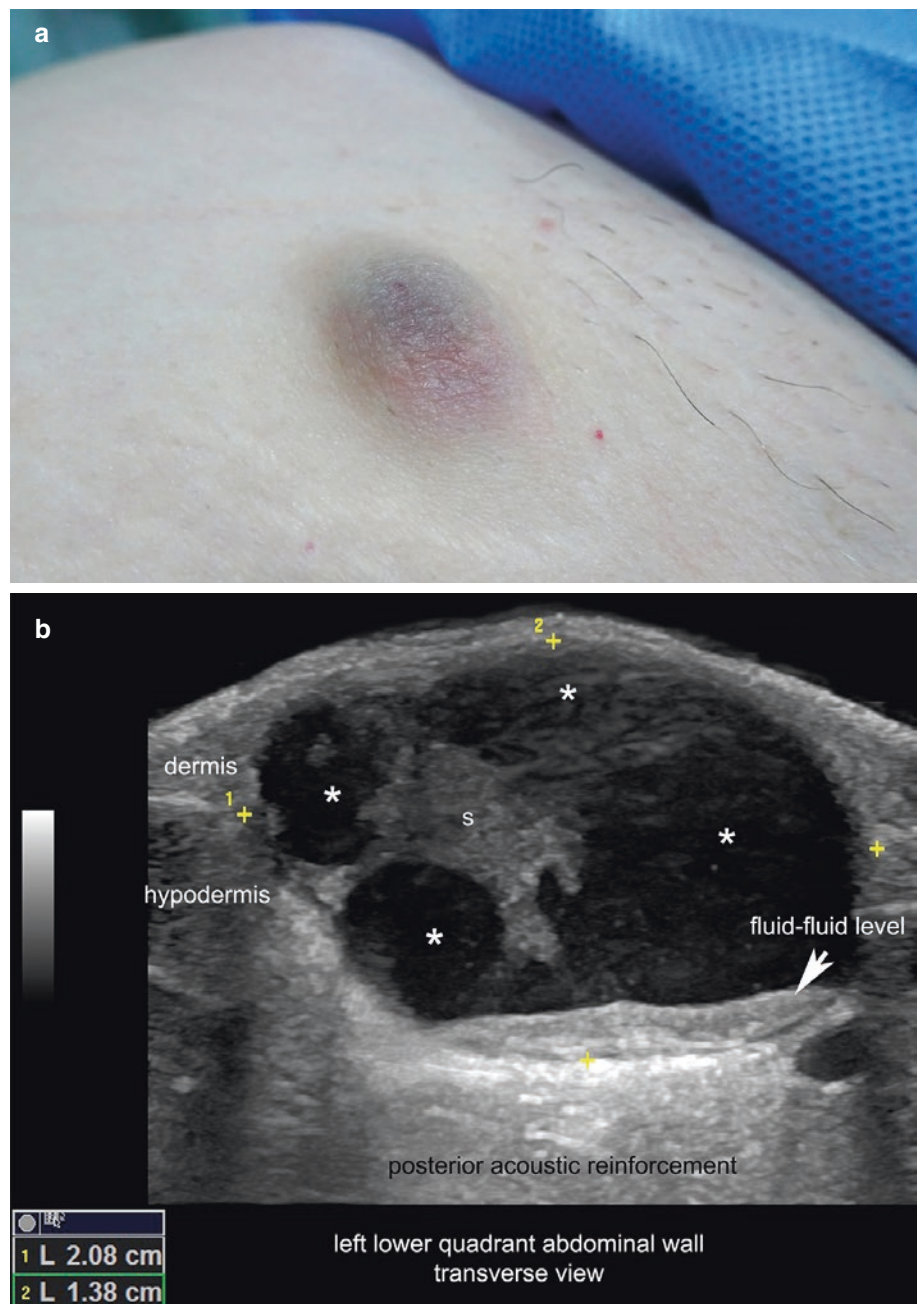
Apocrine hidradenoma. (a) Clinical image at the left lower quadrant of the abdominal wall. (b) Ultrasound (greyscale; transverse view) demonstrates a well-defined, oval-shaped, dermal and hypodermal structure with hypoechoic solid areas and anechoic lacunar areas (asterisks). There are some septa and a fluid-fluid level sign. (c) Color Doppler shows vascularity within the hypoechoic solid part of the nodule. See Video 3.3.
